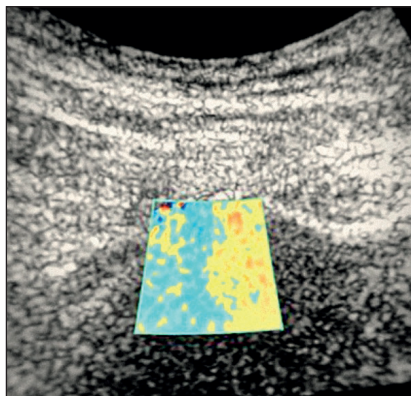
Use of color Doppler flow to locate needle placement.
